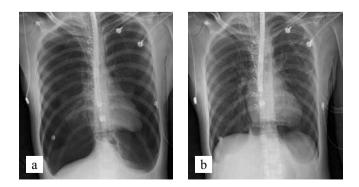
Chest radiograph: a, bilateral spontaneous pneumothorax in a heart-lung recipient after transbronchial lung cryobiopsy; b, condition after drainage of the thoracic cavity
